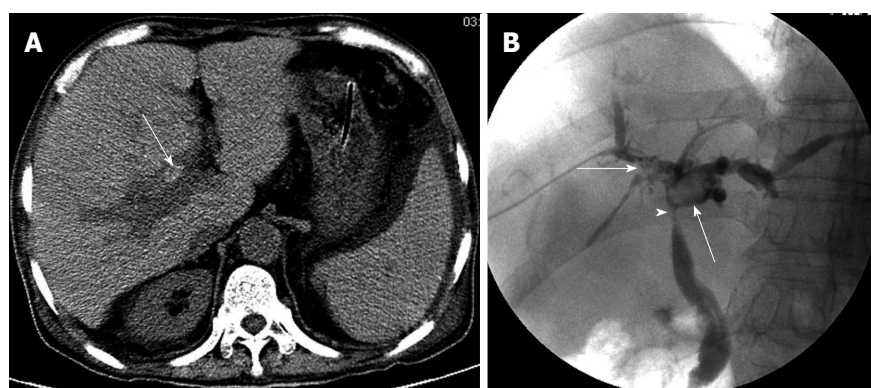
A 57-year-old man with jaundice due to biliary stones and anastomotic biliary strictures 13 mo after orthotopic liver transplantation. A: Transverse plain computed tomography image shows a high-density focus at the hepatic hilar region (arrow); B: Percutaneous transhepatic cholangiography demonstrates filling defect (arrow) caused by biliary stone or sludge in the hepatic hilar bile ducts, and anastomotic biliary strictures (arrowhead).
